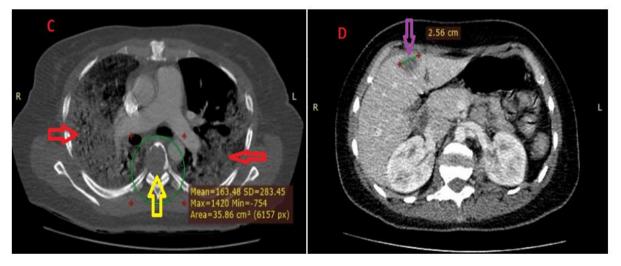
Thoracic and abdominal CT scan: axial section on the thoracic stage passing through the bifurcation of the pulmonary artery (C), showing diffuse bilateral pulmonary parenchymal lesions (red arrows) and T6 vertebral body osteolytic lesion (yellow arrow); axial section on the abdominal floor passing through the hilum of the kidneys (D), objectifying a hypodense nodular lesion of liver segment IV.
